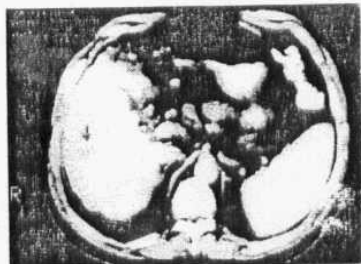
(a): DS-CT demonstrated a metastatic lesion not detected by CTAP (b) of the same patient.
